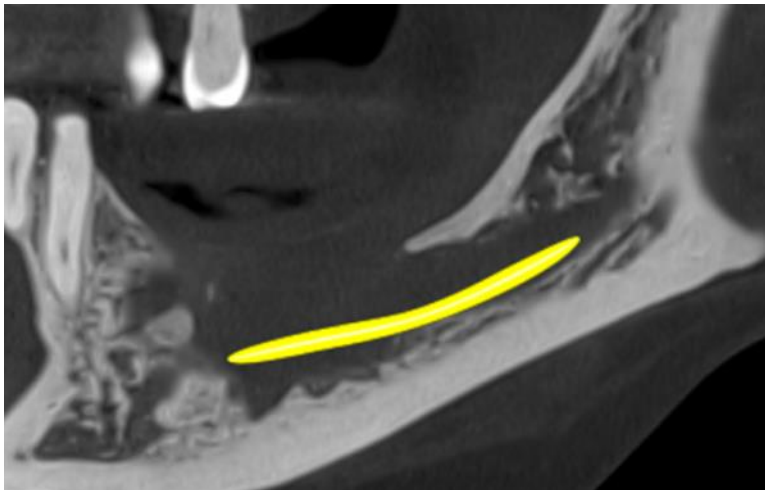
CBCT scan evidenced a surgical defect with possible healing new bone formation
